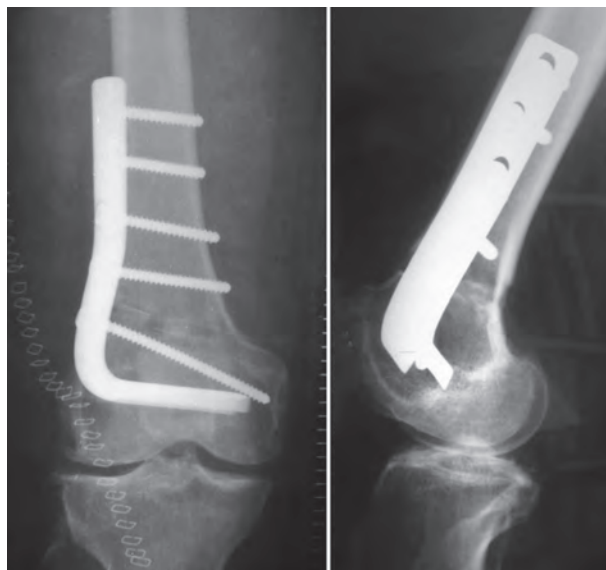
Postoperative radiographs of a 50 year old patient who presented with an idiopathic genu valgum of 188°.
